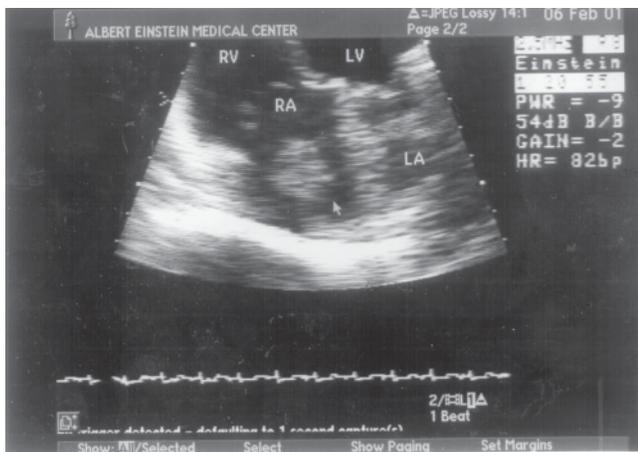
Trans-esophageal echocardiography showing the presence of thrombus in the right atrium of the heart (arrowhead). RA = right atrium; RV = right ventricle; LV = left ventricle; LA = left atrium.
